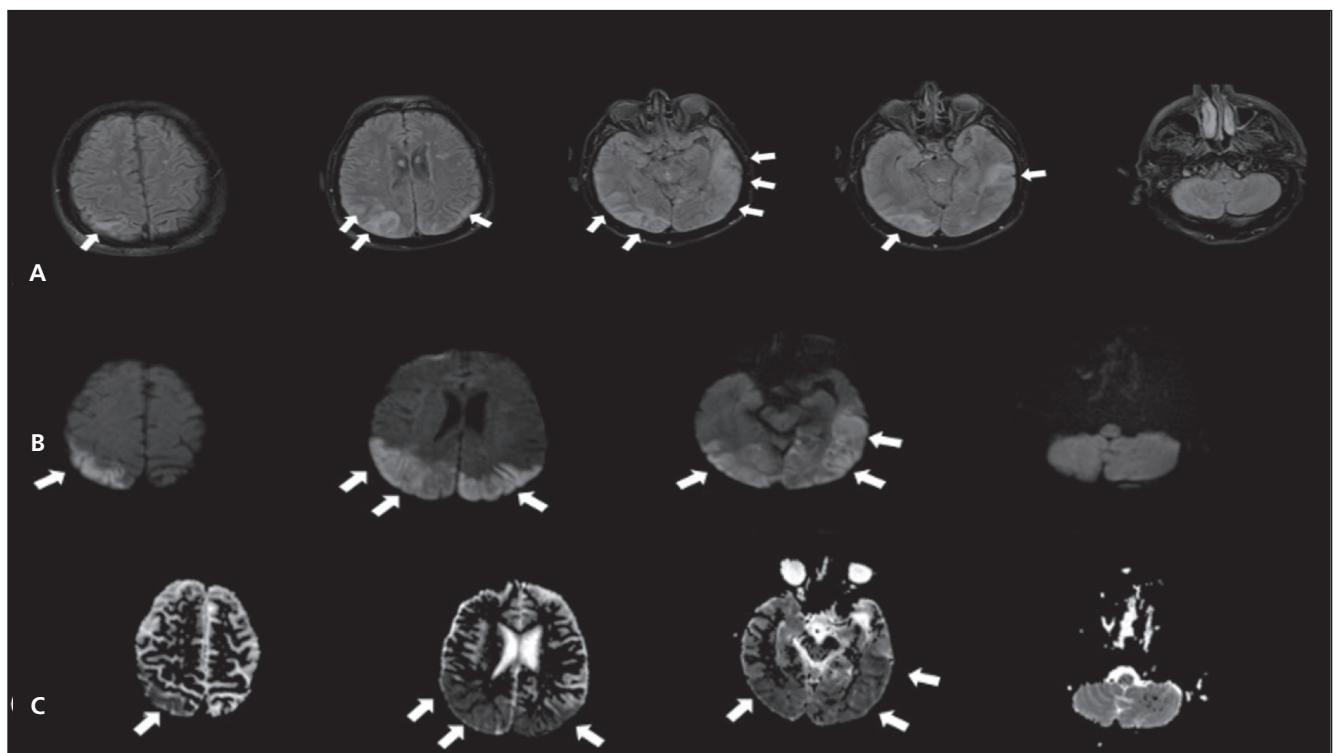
Images on cranial MRI of a 71-year-old man with PRES at diagnosis. (A) Axial T2-weighted FLAIR images showed hyperintensity signals reflecting vasogenic brain edema in the cortical and subcortical areas of the bilateral parietal, occipital, and left temporal lobes. (B, C) Diffusion-weighted images and ADC maps at 1000 s/mm<sup>2</sup> show hyperintense areas in bilateral parietal, occipital, and left temporal lobes.
